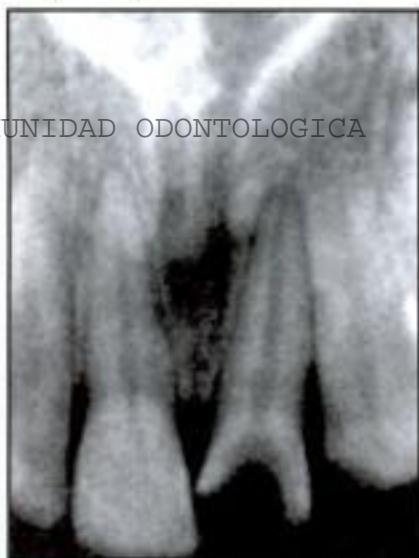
Radiograph showing coronal destruction of tooth because of caries
